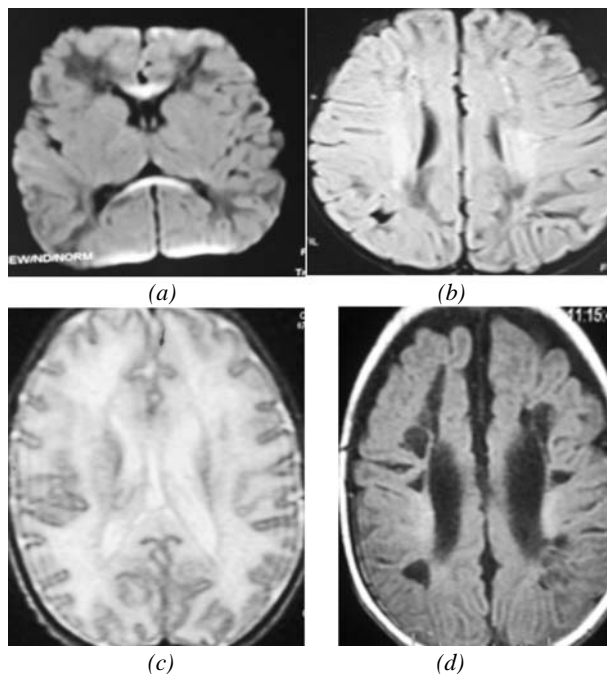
MRI findings in a 15-day-old neonate with encephalopathy secondary to mother to child transmission of chikungunchikungunya virus infection: (a) Diffusion-weighted image showing hyperintense signal in corpus callosum; (b) FLAIR image showing hyperintensity in bilateral centrum semiovale. 2c and 2d: MRI findings in a 20-day-old neonate: (c) T2-weighted axial scan showing areas of hyperintensity in periventricular and frontoparietal white matter; (d) Follow-up scan after 3 months, FLAIR axial image showing altered signal intensity in bilateral deep white matter with cystic changes and dilated lateral ventricles.
